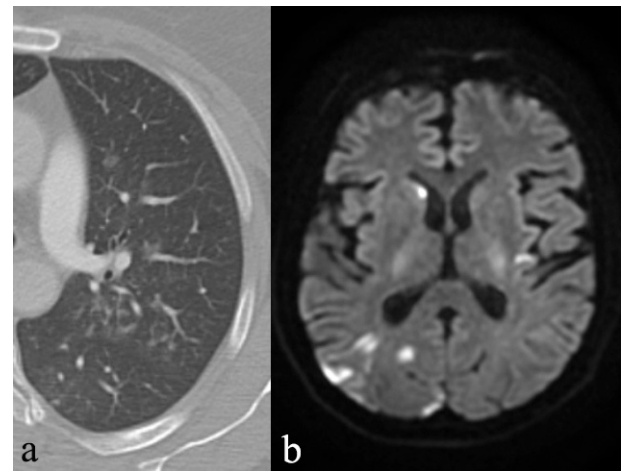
Focal ground-glass opacities in the left lung of COVID-19 infection (a), cranial diffusion MR image of the same patient (b) foci showing diffusion restriction from acute ischemic stroke
